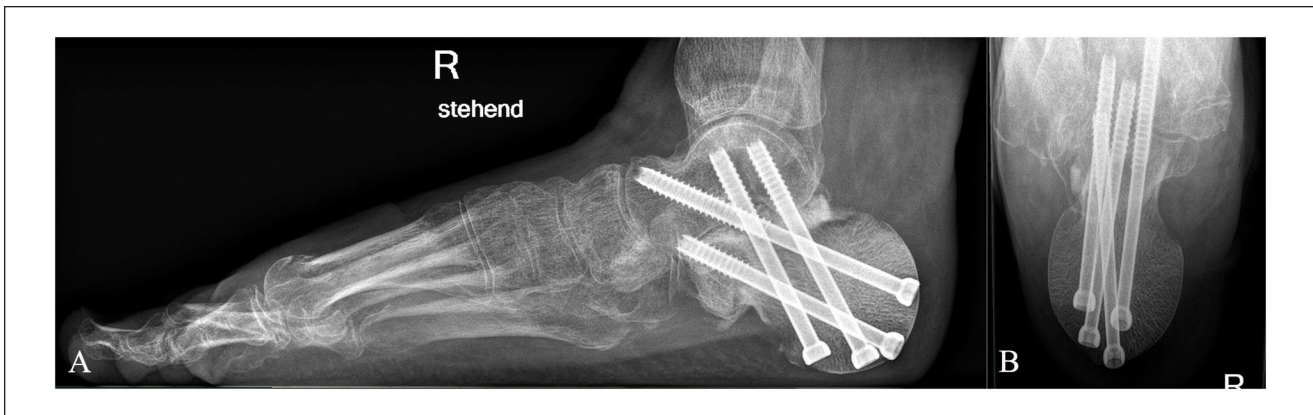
(A) Lateral and (B) axial radiographs of the calcaneus 12 months postoperatively showing fusion between the residual calcaneus anteriorly and the collum femoris and between the talus and the allogeneic strut graft in the subtalar joint without evidence of screw loosening or implant failure.
